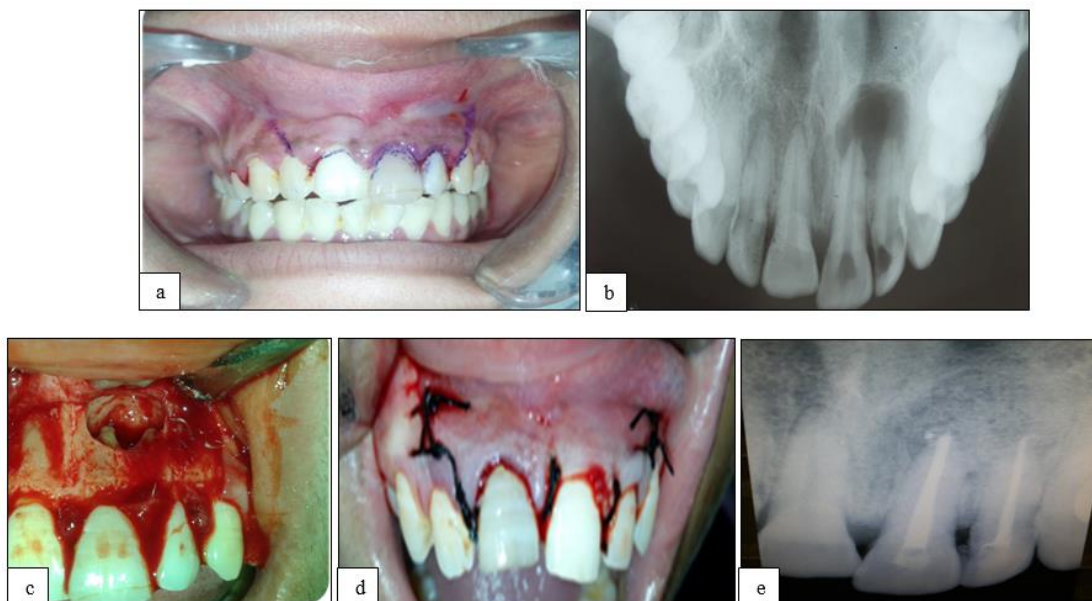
Preoperative #21; b: Preoperative radiograph; c: Flap raised and defect exposed; d: Suturing done; e: Radiograph after 3 months
